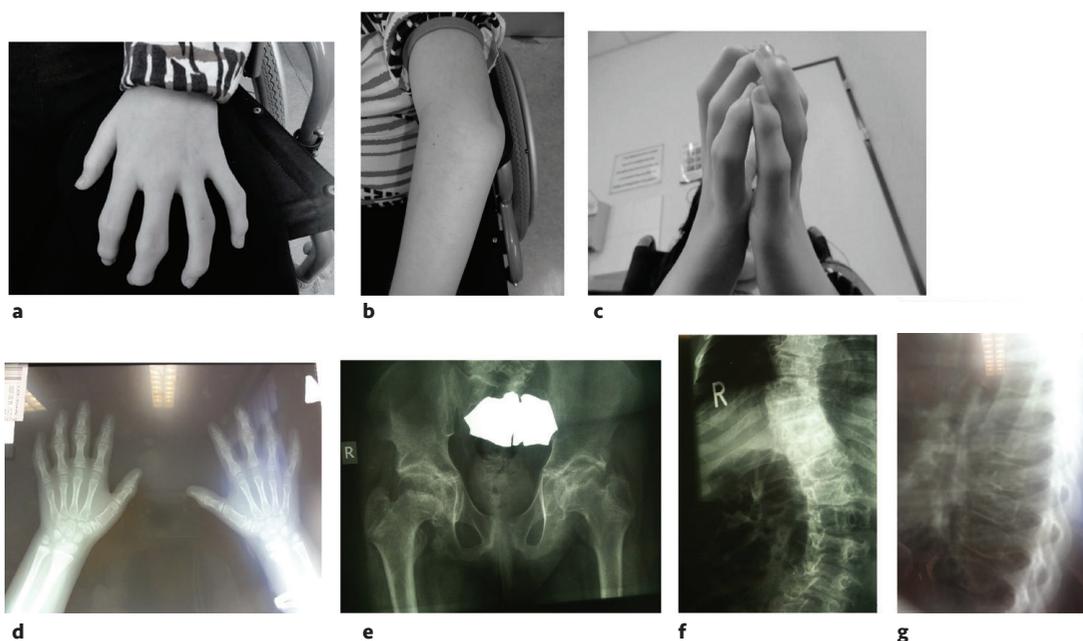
Patient 13 years old: Enlargement and contractures of metacarpophalangeal and interphalangeal joints (a) with limitation of extension of the fingers (b); and enlargement and contractures of the elbow (c). Hand X-rays showing osteopenia, enlargement of the metaphyses and epiphyses at the metacarpals and phalanges, with loss of joint space, without erosions (d). Coxofemoral X-rays showing severe degenerative changes (e) and spine X-rays showing severe scoliosis (f) and flattened thoracic and lumbar vertebral bodies with irregularities of their surfaces (platyspondyly) (g)
